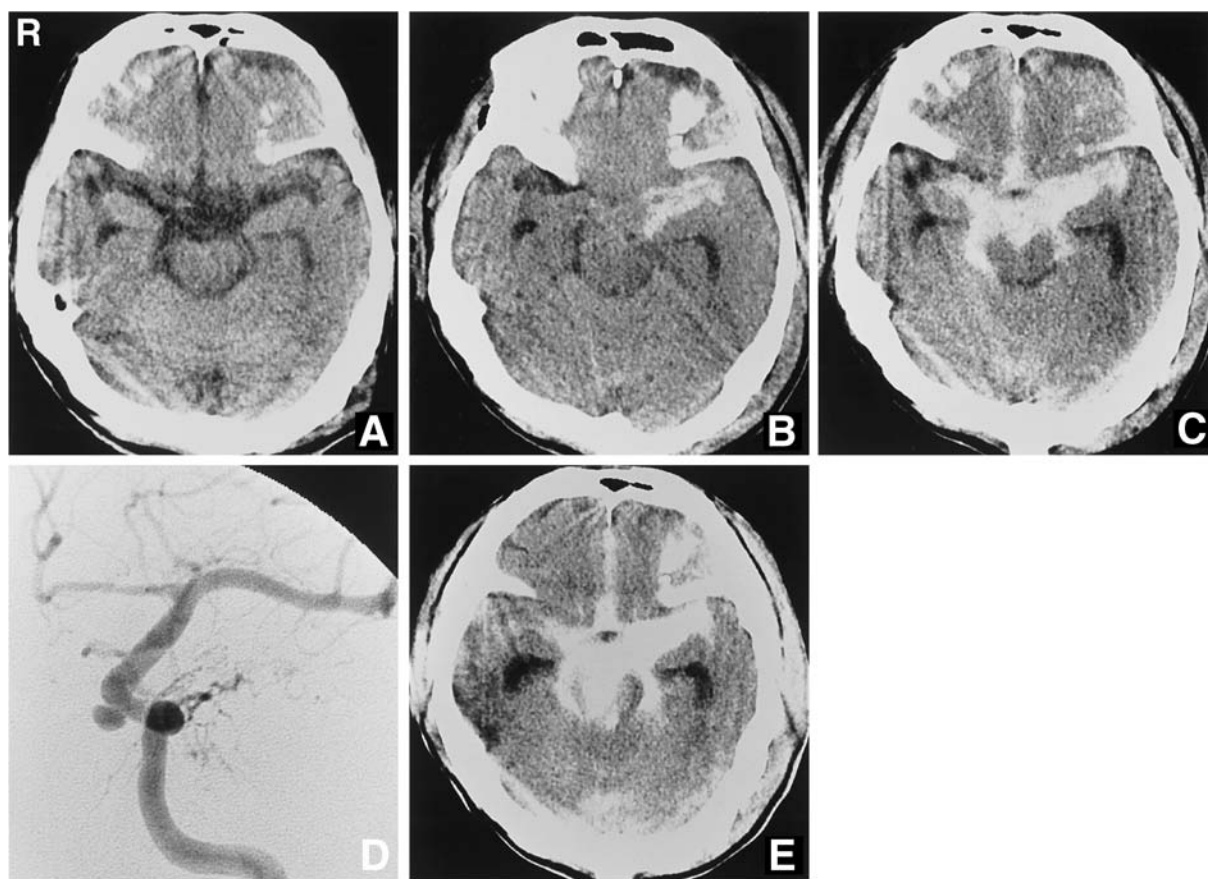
Computed tomography (CT) scans performed immediately (A), 5 hours (B), and 15 hours after the trauma (C). The initial CT scan of the brain shows no abnormalities, but subsequent CT scans show increasing subarachnoid hemorrhage in the basal cistern. Digital subtraction angiogram, anteroposterior view, of the left internal carotid artery performed 18 hours after the trauma (D) showing a normal left middle cerebral artery and a traumatic aneurysm located immediately proximal to the origin of the ophthalmic artery. CT scan performed after angiography (20 hours after the trauma) (E) showing further increase of the subarachnoid hemorrhage in the basal cistern, suggesting rerupture of the traumatic aneurysm.
